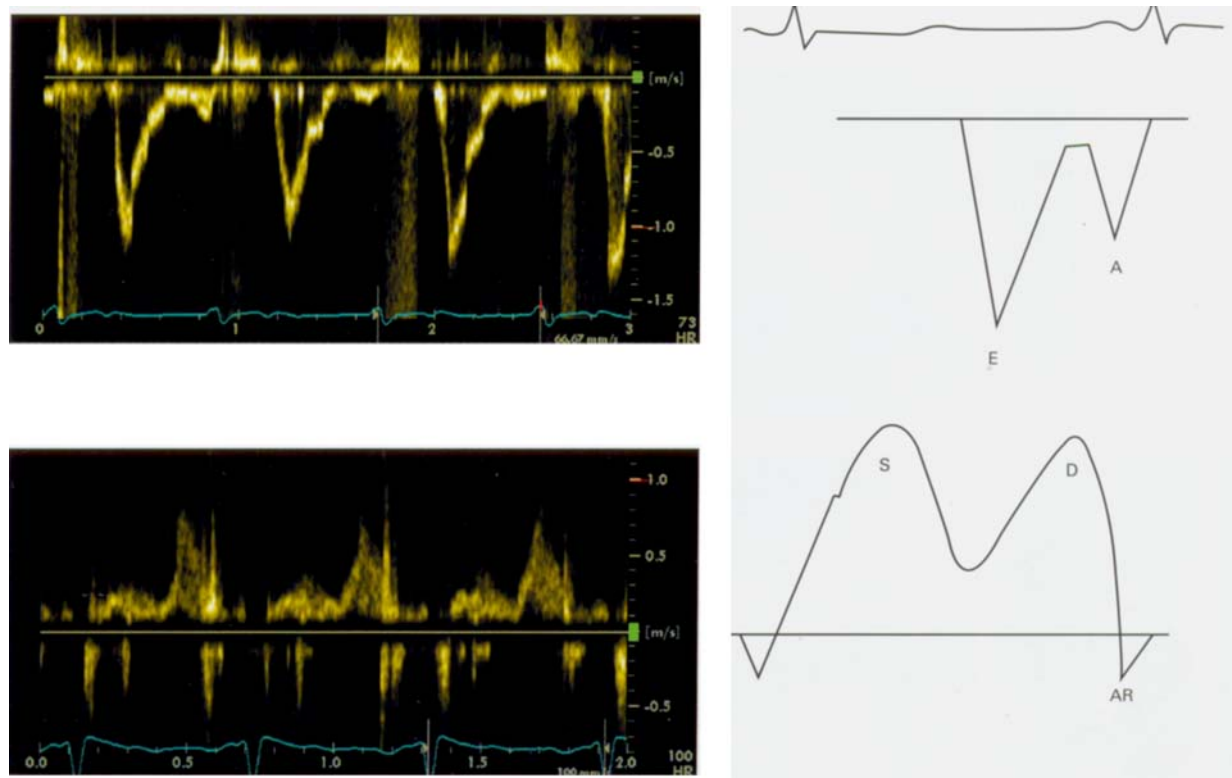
Pulsed Doppler echocardiographic recording of transmitral and pulmonary venous flow velocity profiles. The depicted transmitral and pulmonary venous flow pattern are indicative of elevated end-diastolic left ventricular pressures. Transmitral flow during diastole is typically biphasic with an early (E) filling wave and a subsequent atrial (A) wave, corresponding to atrial contraction. The ratio of E/A peak transmitral velocity is age dependent, but in normal adult patients it is close to 1. In the pulmonary veins blood flow is antegrade throughout systole (S wave) and diastole (D wave). Most normal adult patients exhibit a prominent systolic flow and a systolic-to-diastolic ratio greater than 1. Retrograde flow occurs during atrial contraction (pulmonary AR wave). Integration of instantaneous pulmonary flow velocities during systole and diastole allows for calculation of the systolic and diastolic fraction, respectively. See text for further details.
